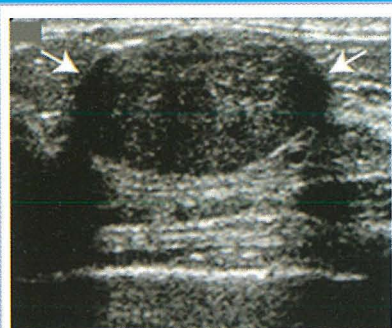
Fibroadenoma seen on ultrasound as a well circumscribed, hypoechoic nodule with dorsal enhancement and a long axis parallel to the chest wall.
